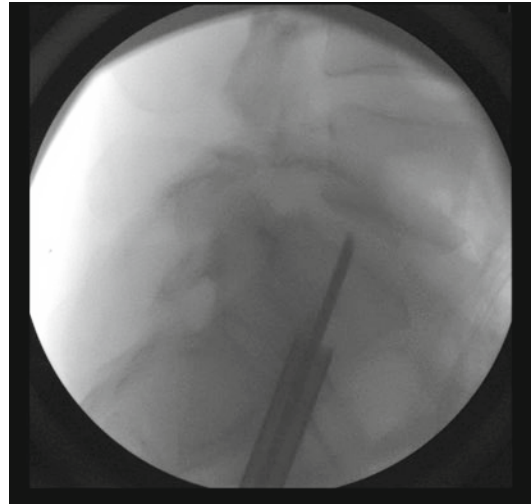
Intraoperative lateral x-ray demonstrating the entry of the presacral guide pin into the L5–S1 disc space and the advancement of a dilator halfway to target
